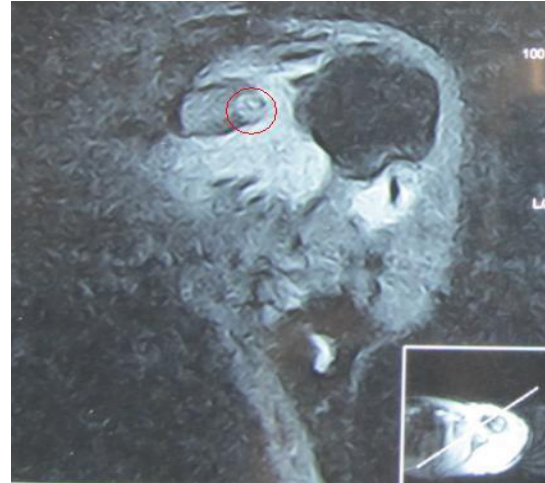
T2-weighted magnetic resonance imaging (MRI).
